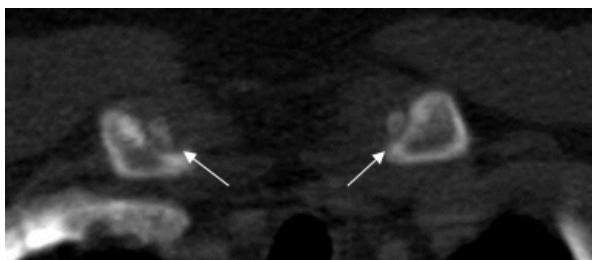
CT image of medial clavicles of a 14 year old female shows stage 2a ossification of bilateral epiphyseal cartilage (white arrows)
